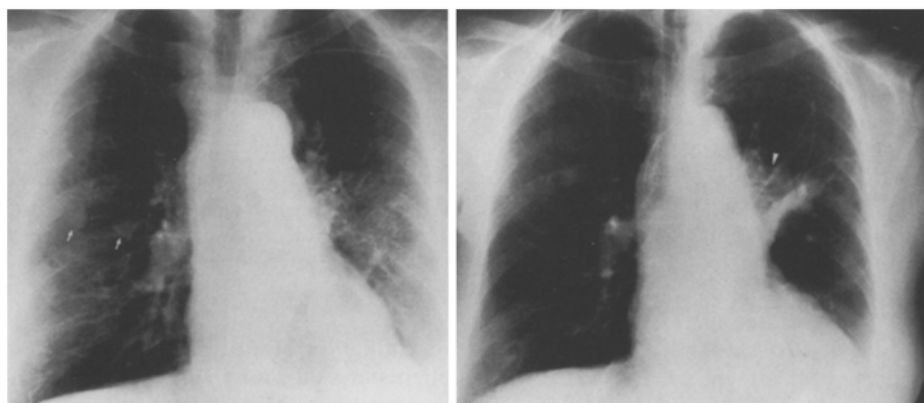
The chest X-rays of patient no. 4 before treatment (31.03.87) and after (21.04.87) application of a cumulative dose of 30×10^6 U/m² rIL-2 (31.03.87–13.04.87) reveal a complete disappearance of metastases (arrows) of the right lung, while an enlarged lymph node tumor (arrow), confirmed by computed tomography scan, developed concomitantly on the left side of the thoracic chest
